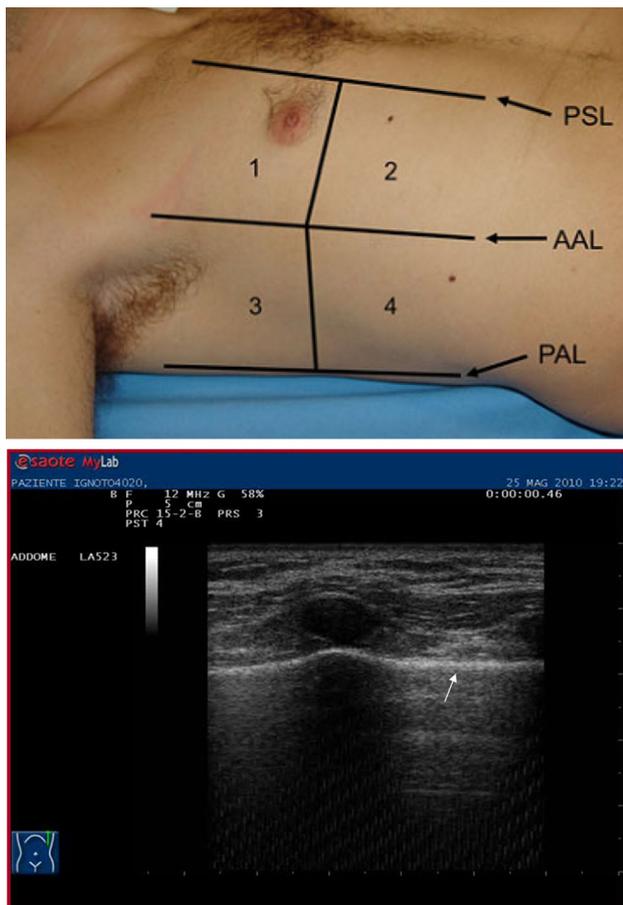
Thoracic ultrasound: echogenic pleural line (*white arrow*); on top, lines of US scans (ParaSternalLine/AnteriorAxillarLine/PosteriorAxillarLine)
